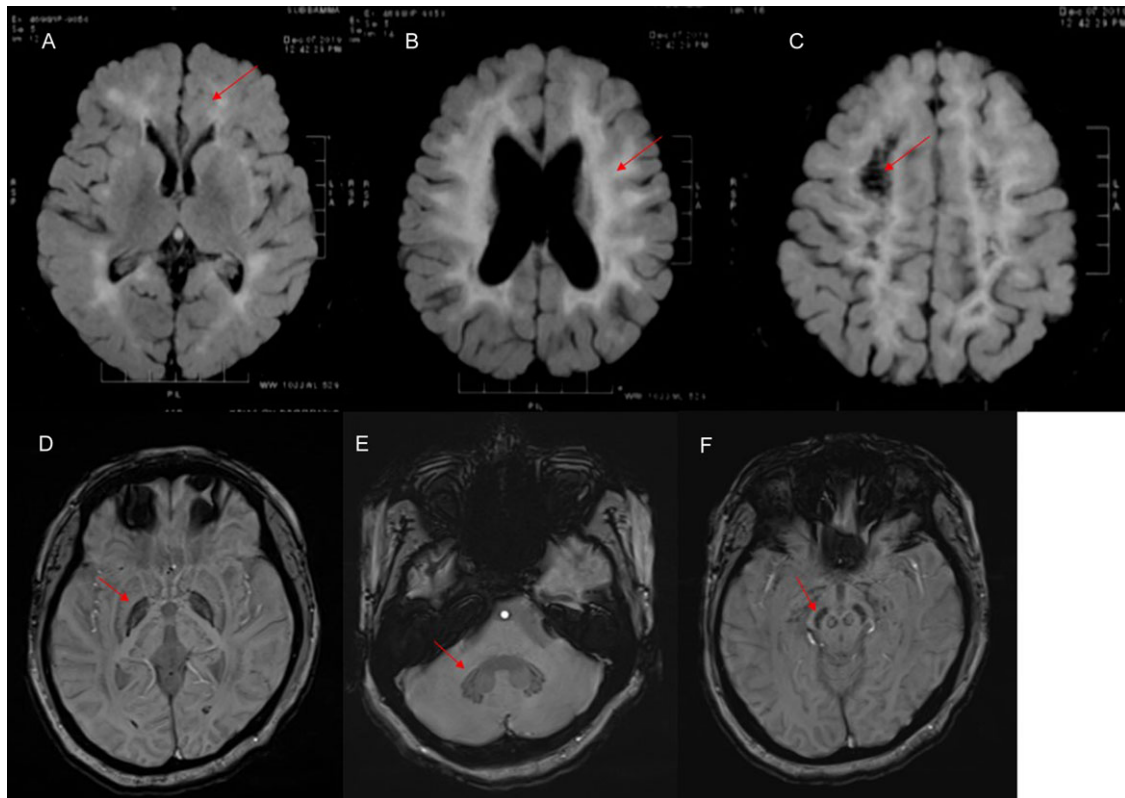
Brain MRI of patient 2. (a), (b) and (c) axial fluid-attenuated inversion recovery images revealing diffuse hyperintense signal of bilateral white matter (a and b) with area of signal suppression suggesting rarefaction (c) (red arrow); (d), (e) and (f) axial susceptibility-weighted image showing mineralization in the globus pallidum, substantia nigra and dentate nucleus (red arrow). MRI = magnetic resonance imaging.
